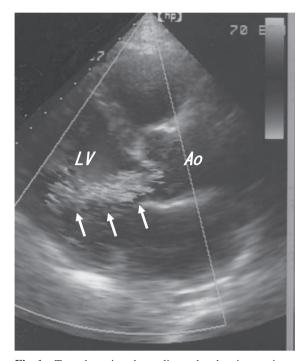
Transthoracic echocardiography showing a tricuspid aortic valve with the grade 3/4 aortic regurgitation (arrows), normal aortic annulus with the 21mm. Ao, aorta; LV, left ventricle
